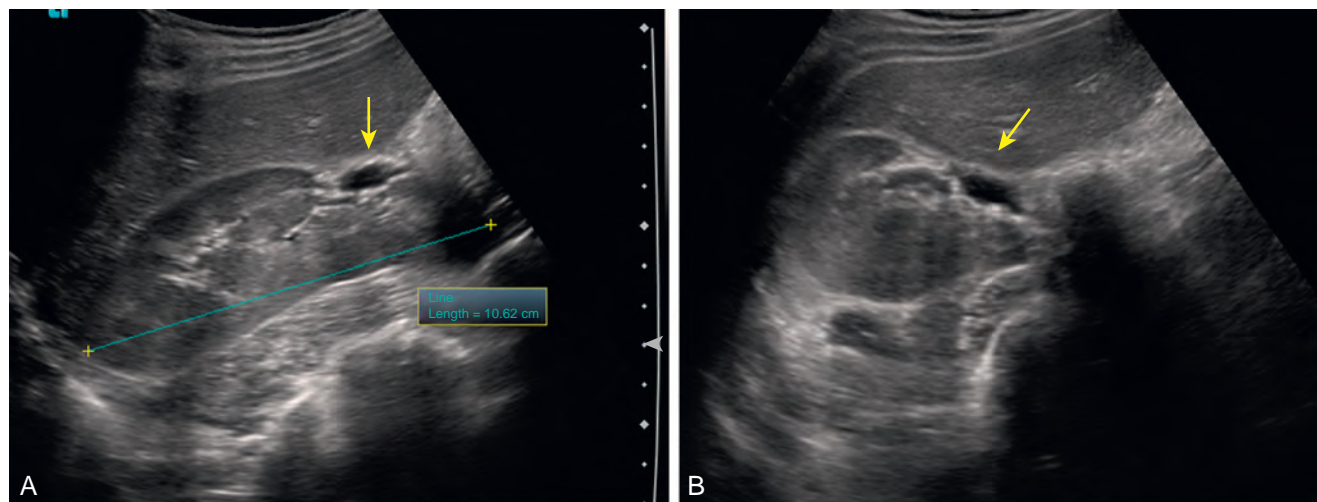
Sonogram showing (A) sagittal view of malrotated right kidney. B, Transverse view of malrotated right kidney. Note the anterior position of the renal pelvis (arrows).
